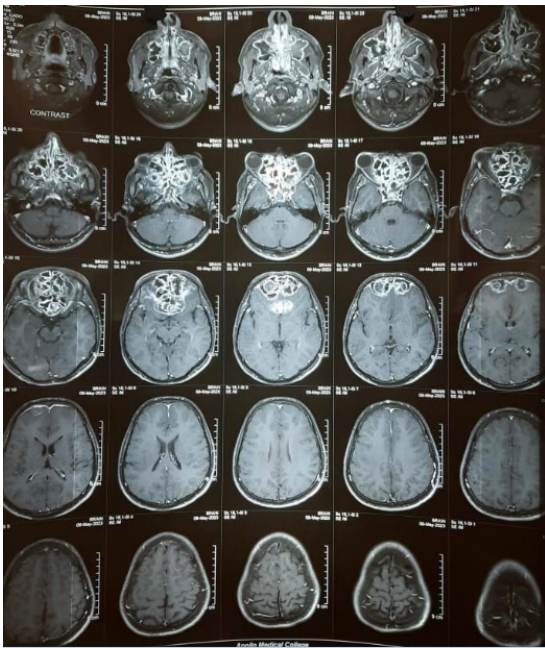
Showing MRI Brain with contrast which showed soft tissue opacification of all paranasal sinuses and bilateral nasal cavities with sinus expansion.
